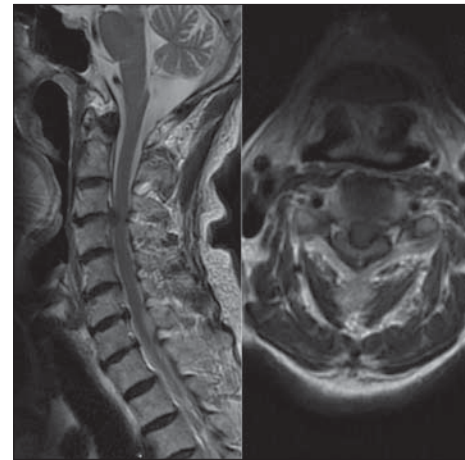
Sagittal and axial cut magnetic resonance images at the C3–C4 level showing large disc herniation causing severe spinal canal stenosis and cord compression
